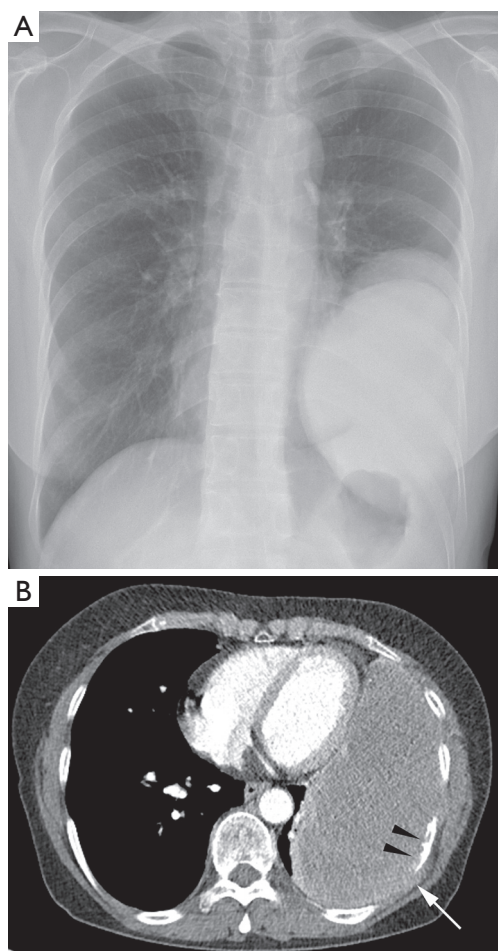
Follow-up chest X-ray and CT scan obtained seven months after surgical resection of pleural mass. (A) Chest X-ray shows a large recurrent mass at the site of previous mass excision; (B) contrast-enhanced CT scan shows a solitary large well-defined homogeneous enhancing mass in the left lower hemithorax. There are sign of bony destruction of adjacent rib (arrowheads) and chest wall invasion (white arrow). Image noise in the mass was owing to the low radiation dose CT scanning with iterative reconstruction algorithm. A 100 kVp and dose modulation of mAs was used.
